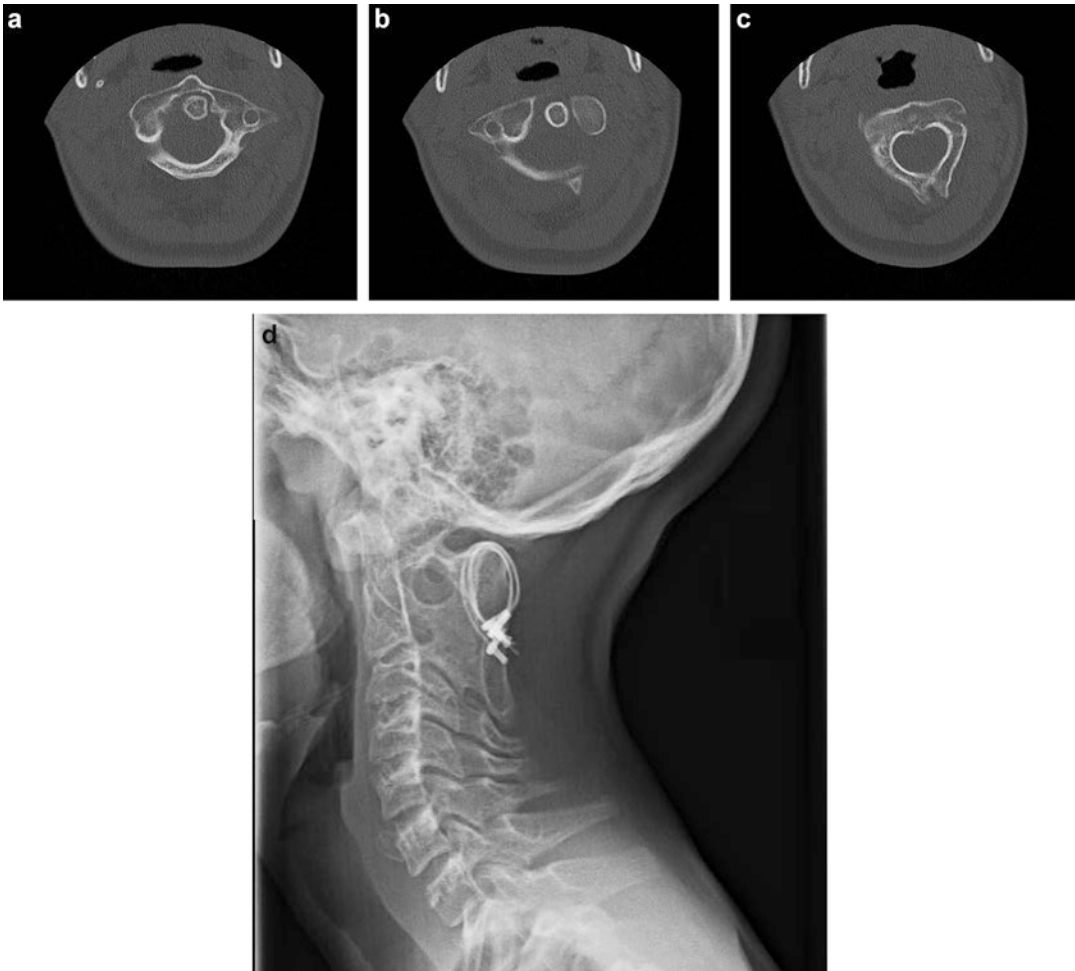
(a–d) Atlantoaxial rotatory subluxation: 11-year-old male presented 3 months following minor neck trauma with a tilted head. CT examination revealed rotatory subluxation of C1 on C2 (a–c). Initial treatment
